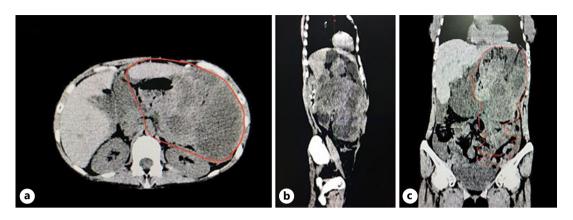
Abdominal CT-scan (axial section (a), sagittal section (b), coronal section (c)). CT, computed tomography.
